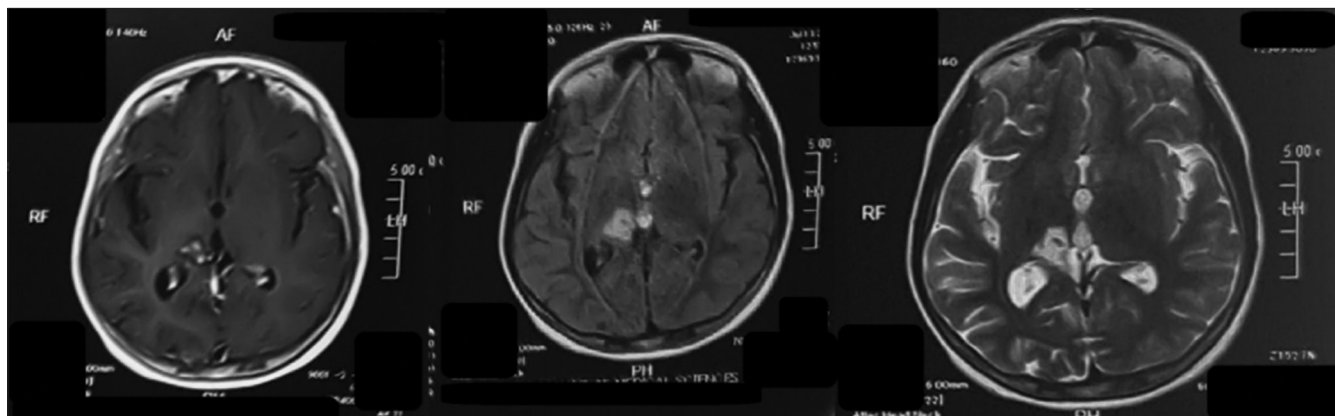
(Left) T1 contrast; (Middle) Fluid attenuated inversion recovery (FLAIR) sequence; (Right) T2 sequence. 8-month follow-up magnetic resonance imaging showing a near complete resolution of the lesion.
